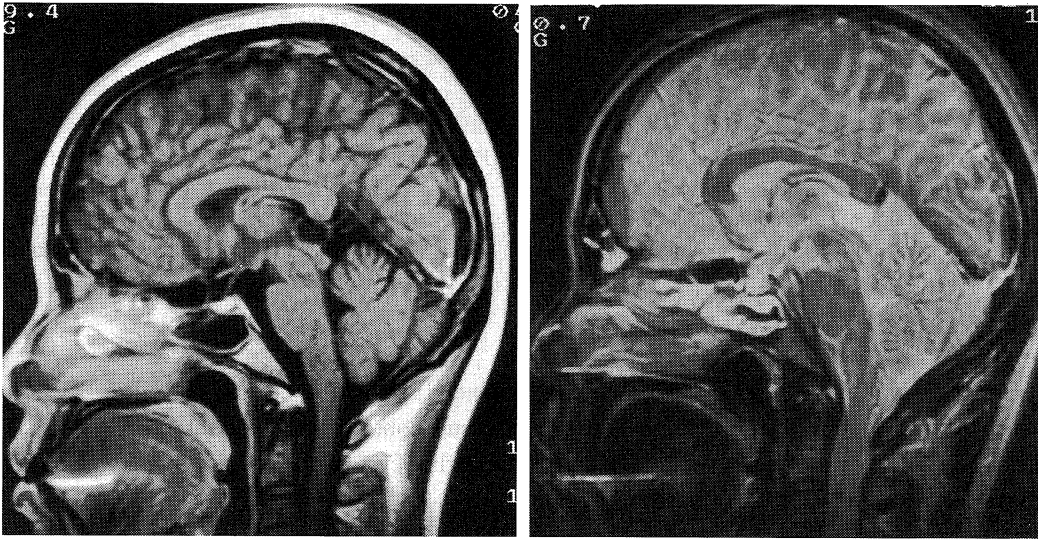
Sagittal T1-weighted image (left) and T2-weighted image (right) showing a round, high signal (T2-weighted image) mass in the pineal region, compressing the superior colliculus.
